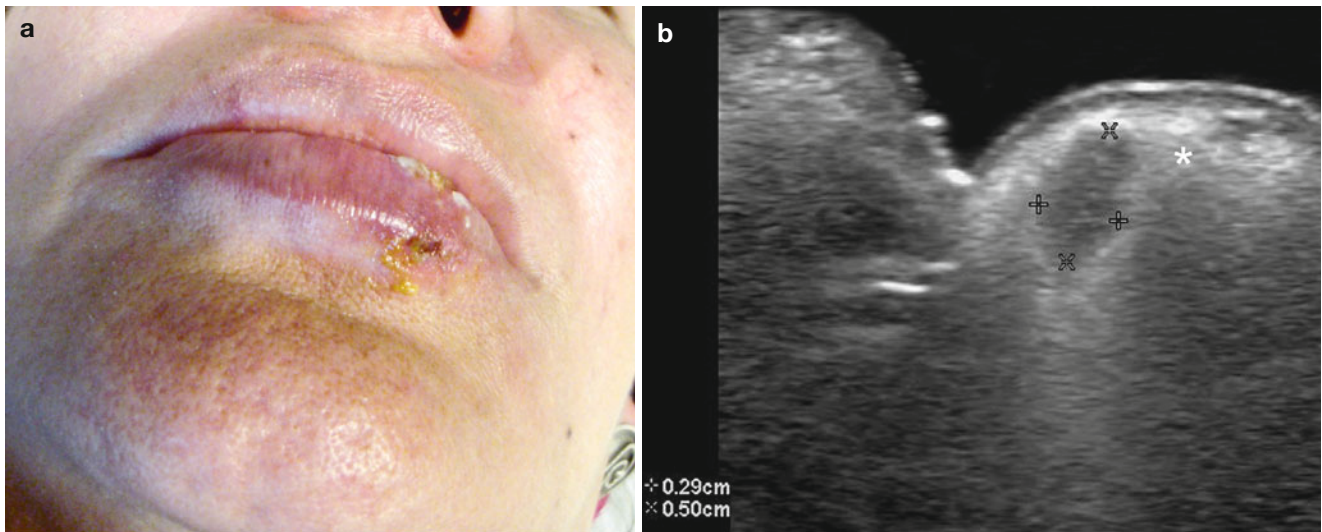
(a, b) Silicone oil and hyaluronic acid complication. (a) Clinical image shows edema and ulceration in the lower lip 1 week after injection of a mixed formulation of hyaluronic acid and lidocaine. The patient had a history of injection of silicone oil in the lips 8 years ago (revealed after the hyaluronic acid injection). (b) Grey scale ultrasound image (longitudinal view, lips) demonstrates a 2.9 mm long \times 5.0 mm
